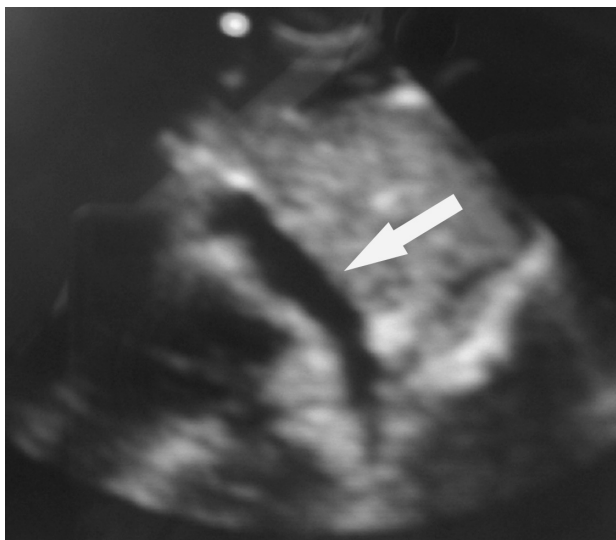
(Bottom, page 120) *Ultrasound (FAST) shows pericardial effusion (arrow).*
